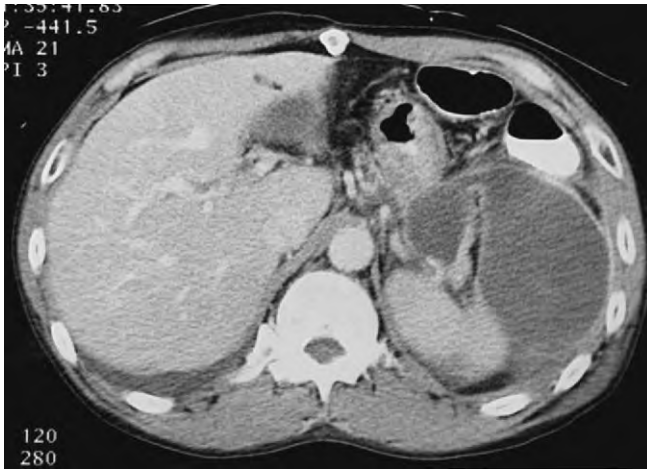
Computed tomography scan of a patient with an acute fluid collection 10 days after an episode of acute alcoholic pancreatitis. The collection is located anterior to the spleen and appears to have a thin wall. The acute fluid collection was not causing symptoms and gradually resolved with observation.
